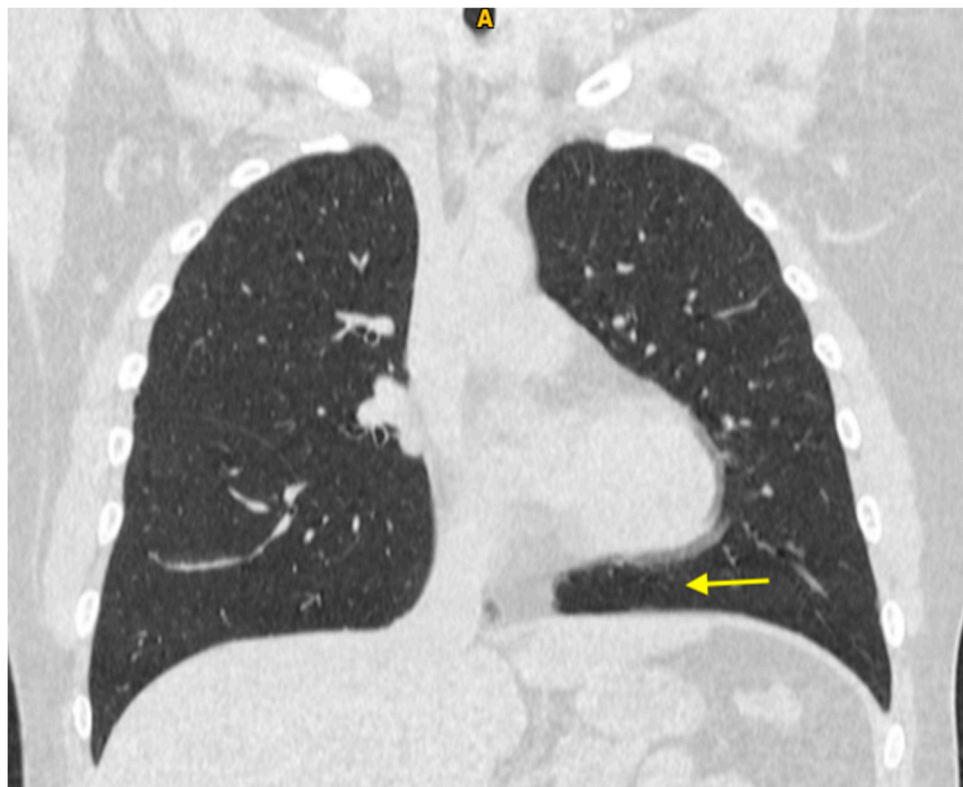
CT of the chest in the coronal plane using a lung window, demonstrating interposition of lung parenchyma between the left hemidiaphragm and the cardiac base (yellow arrow).
